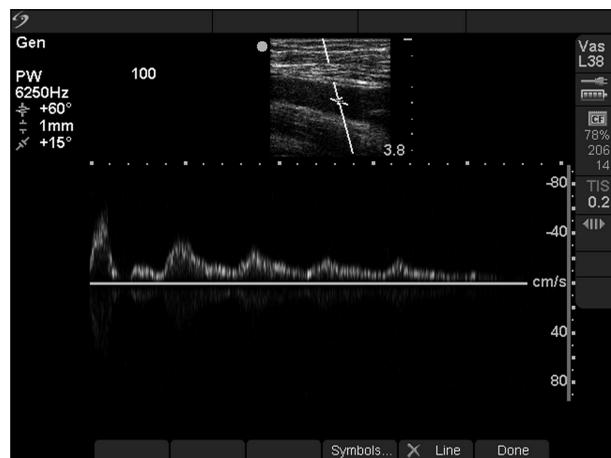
Tracing obtained at the common femoral artery with a 100-pound dumbbell being lowered slowly over the distal abdominal aorta. The Doppler tracing portion of the ultrasound image shows a sequentially decreasing size in the arterial velocity as more of the weight is allowed to rest on the abdomen. All traces of blood flow disappeared in this subject once the 100-pound weight was allowed to rest completely over the aorta.
